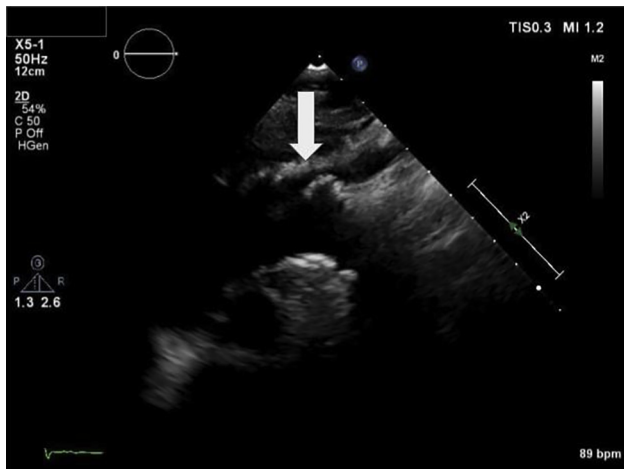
Two-dimensional transthoracic echocardiography suprasternal view displaying narrowing of the brachiocephalic trunk (arrow).
